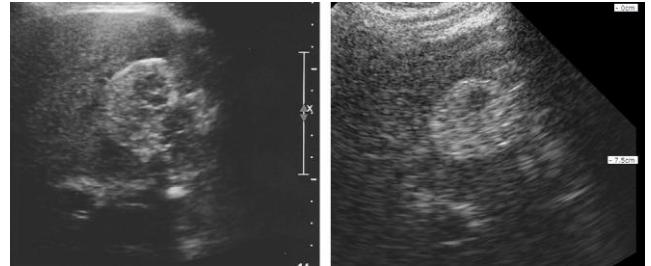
Image of liver obtained using standard ultrasound machine in hospital radiology departments (14cm) (left) and using our prototype (15cm) (right).
